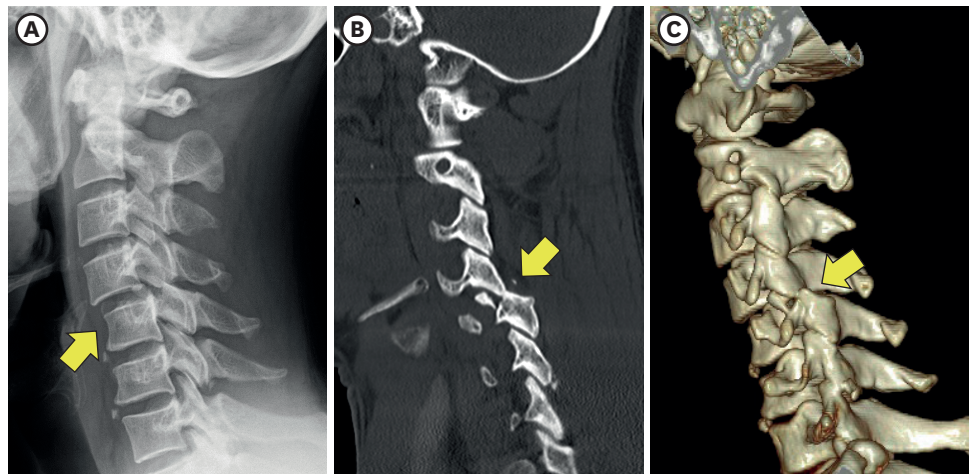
Facet fracture aggravated to facet interlocking. Cervical lateral X-ray (A), sagittal images (B) and 3D (C) of CT on 3 days after discharge showed anterior slippage of C4 body with unilateral facet interlocking and a bony fragment of C5 superior articular process was pushed forward by locked inferior articular process of C4 encroaching the neural foramen (yellow arrow: A) C5 vertebra B&C) locked facet of C45).
